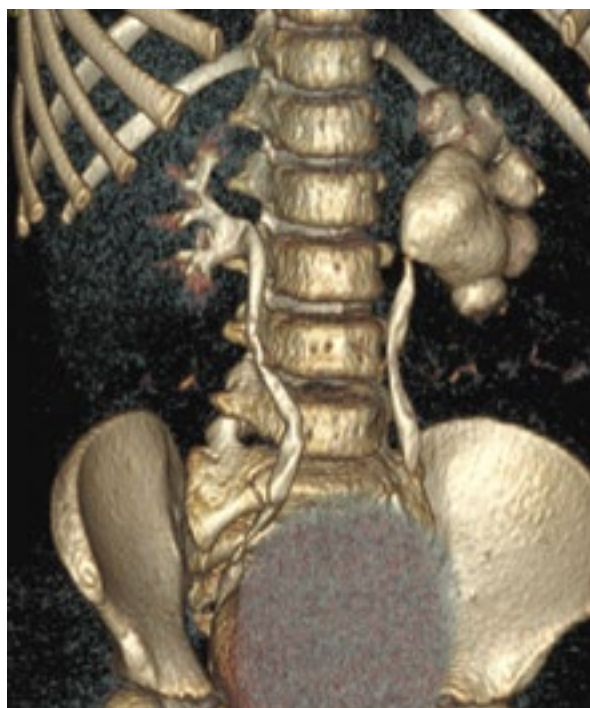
Left-sided hydronephrosis: CT urography, 3D reconstruction
